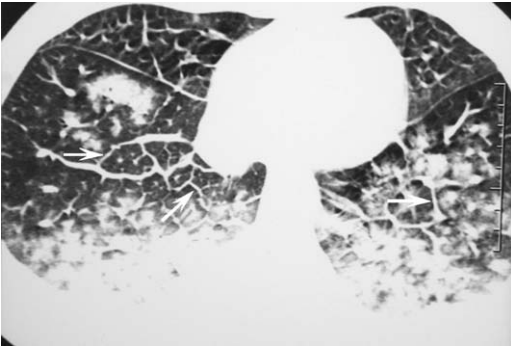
Smooth interlobular septal thickening: pulmonary edema. Axial HRCT shows extensive smooth interlobular septal thickening (*arrows*) in the lung bases of a patient with congestive heart failure. Note presence of centrilobular nodules without tree-in-bud opacity.
